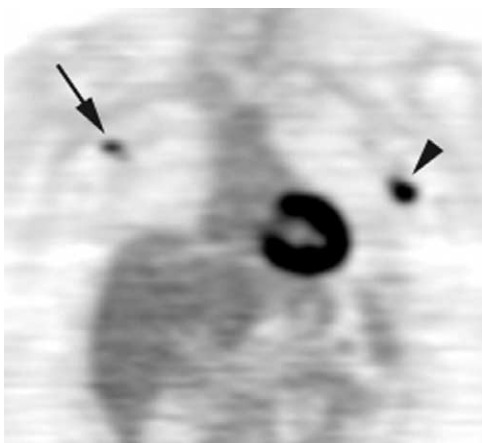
A 54-year-old woman with left axillary recurrence (biopsy-proven) 17 years after initial diagnosis of malignancy in the contralateral breast. A new primary cancer in the left breast was not detected by mammography or sestamibi scan and there was no evidence of distant metastases on CI (chest CT and bone scan). FDG-PET, performed to exclude distant metastases, shows uptake in the right axilla (arrow; SUV = 6.8) in addition to the left axilla (arrowhead; SUV = 7.4). Management plan was altered from left modified radical mastectomy and axillary lymph node dissection to systemic chemotherapy after malignancy was confirmed in right axilla by biopsy.
